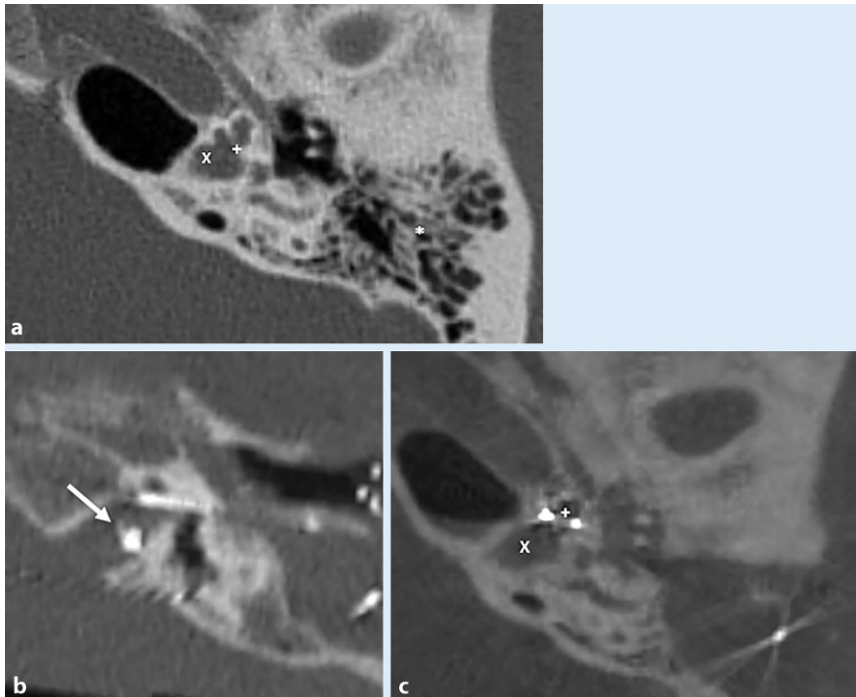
▲ Prä- und postoperative Computertomographie (CT) und digitale Volumentomographie (DVT) von Patienten mit IP III („incomplete partition type III“). a Präoperative CT, Darstellung der cochleären Basalwindung (+) und der fehlenden knöchernen Begrenzung (X) zwischen Basalwindung und erweitertem innerem Gehörgang (IAC). * Mastoid. b Postoperative DVT-Aufnahme mit einem dislozierten Elektrodenträger im IAC (Pfeil). c Postoperative DVT-Aufnahme mit dem Elektrodenträger innerhalb der cochleären Basalwindung (+), fehlende Lamina cribrosa und IAC (X)
